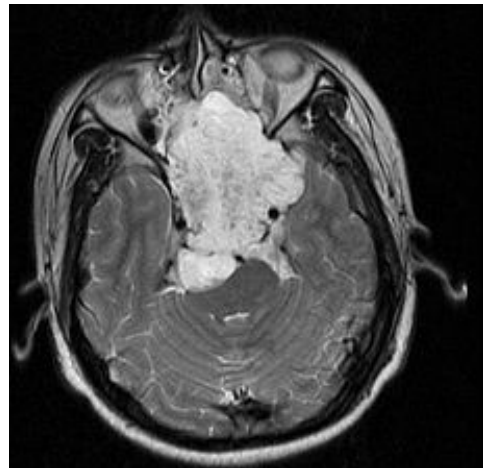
MRI of Clival Chordoma., T2W axial view showing large hyper intense mass with extension to in the nasopharynx, and left pterygopalatine fossa.
